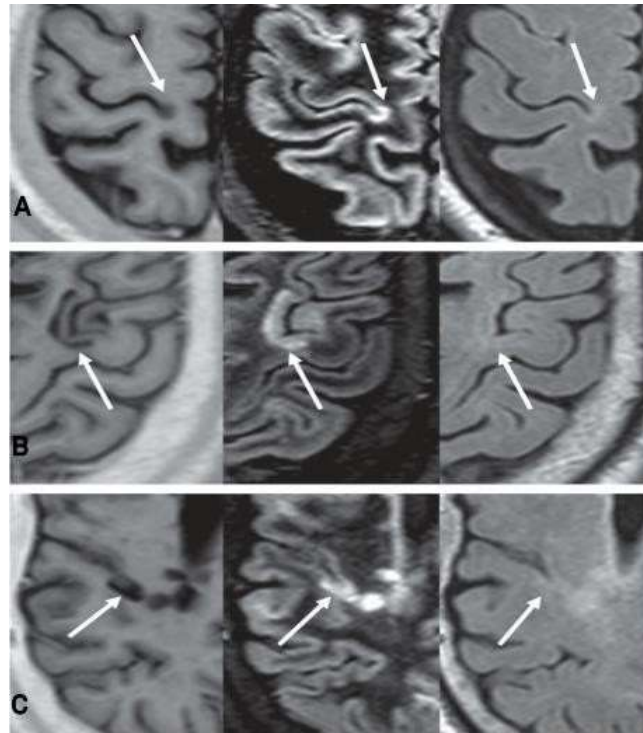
Cortical lesions on PSIR (left), DIR (center), and FLAIR (right). PSIR sequence is more sensitive in the detection of intracortical lesions (A), juxtacortical (B), and leukocortical (C).
